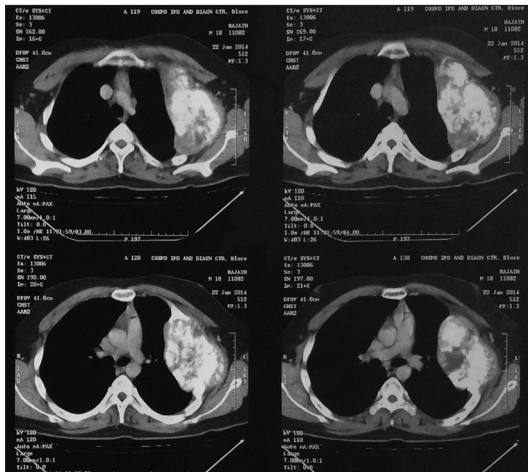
Computed tomography scan shows a heterogenous calcified lesion in left 2nd and 3rd rib with areas of necrosis
